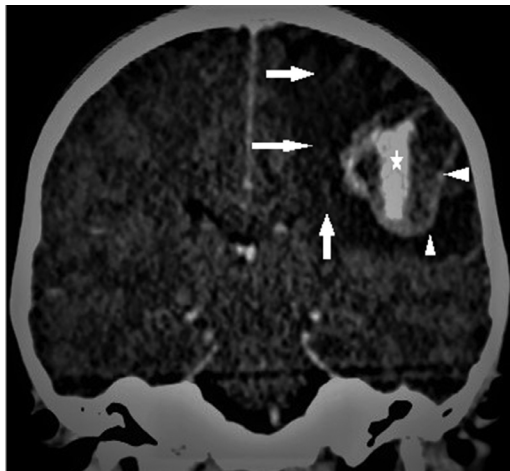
Brain enhanced CT in venous phase: perilesional oedema (arrows), peripheral enhancement (arrowheads) and an intralesional aneurysm (star).
